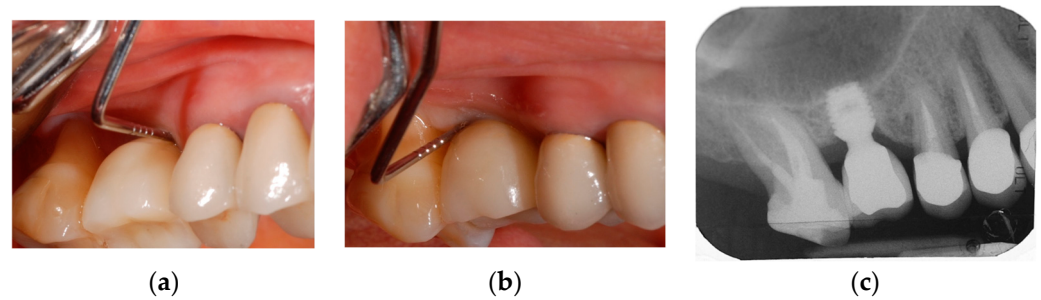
Clinical photographs obtained after 5 years from surgery time: see stable soft tissue conditions with absence of bleeding and decreased PPD (a,b). A radiograph was obtained after 5 years from surgery time: see bone gain (c).
